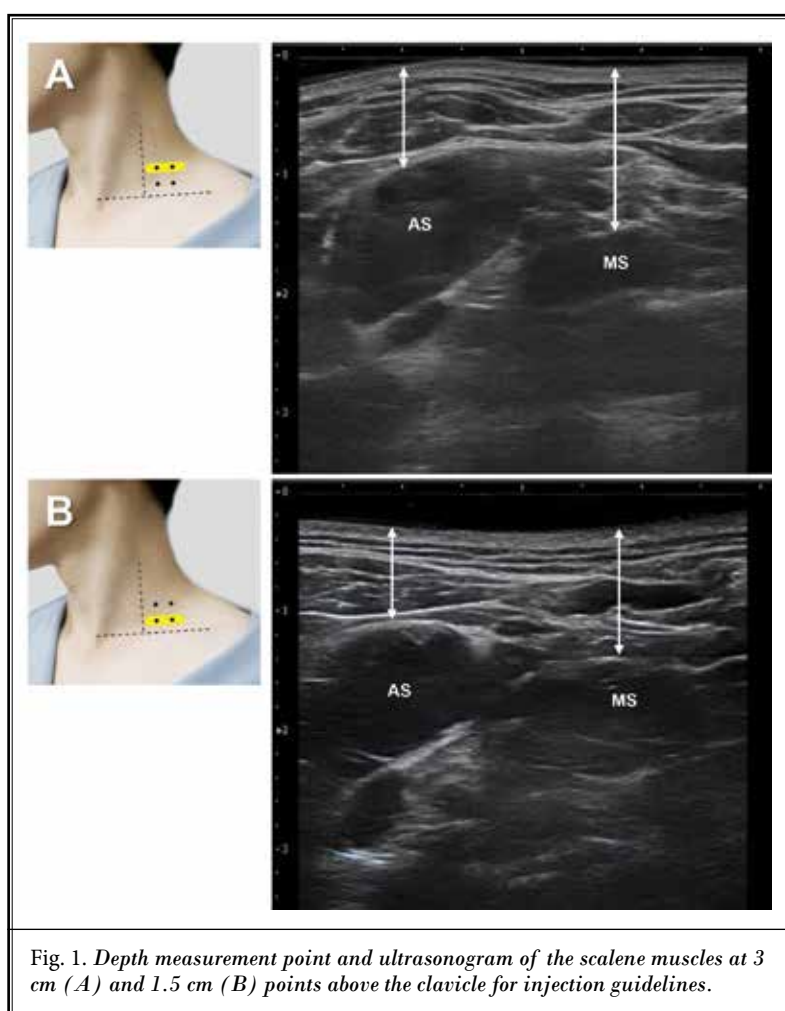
Depth measurement point and ultrasonogram of the scalene muscles at 3 cm (A) and 1.5 cm (B) points above the clavicle for injection guidelines.
